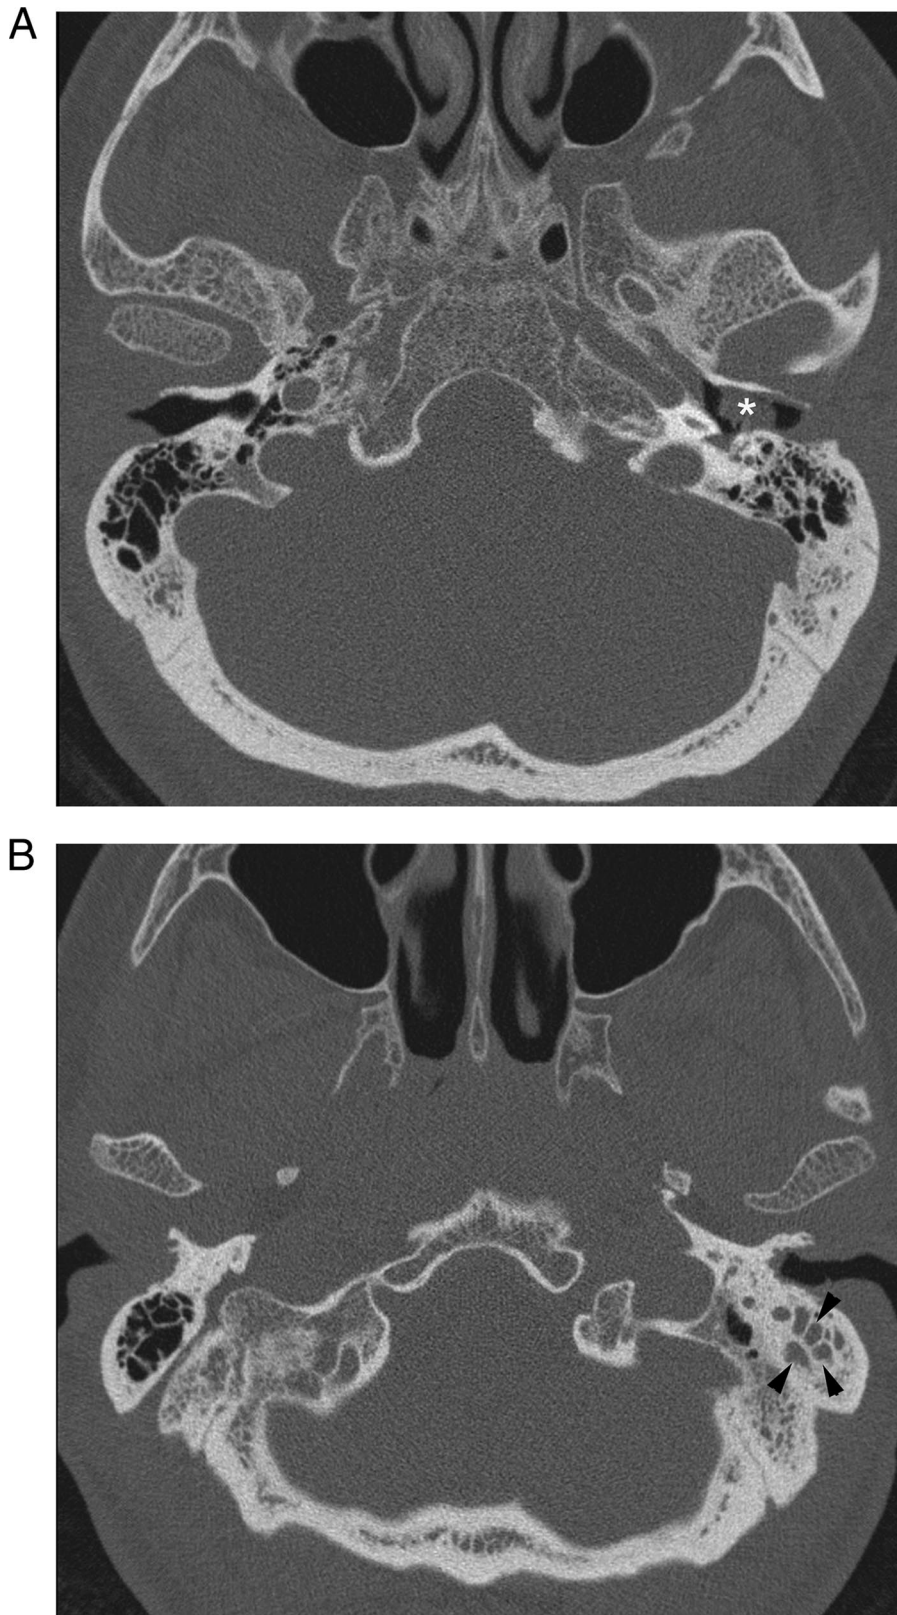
Axial CT scans of the temporal bone (image B was obtained inferior to image A) show soft tissue (*) filling the left external auditory canal and abnormal soft-tissue attenuation (arrowheads) in the left inferior mastoid air cells (compare with the opposite side).
